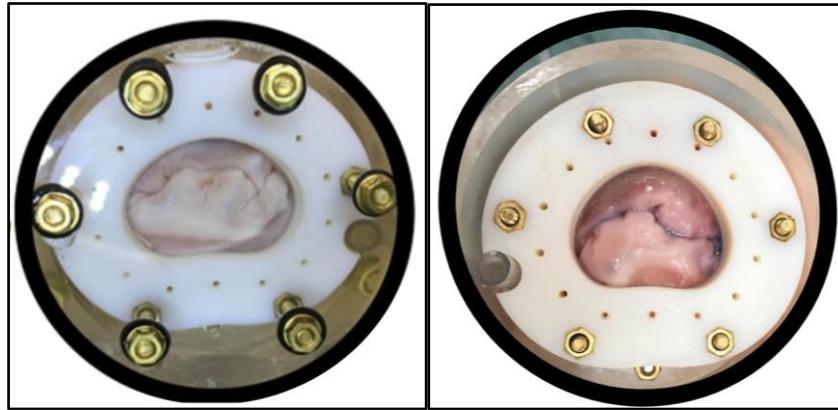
MV leaflet closure for MRI using fluid pressure (5). Figure 5B: MV leaflet closure using air pressure with Vetbond adhesive for μ CT.
